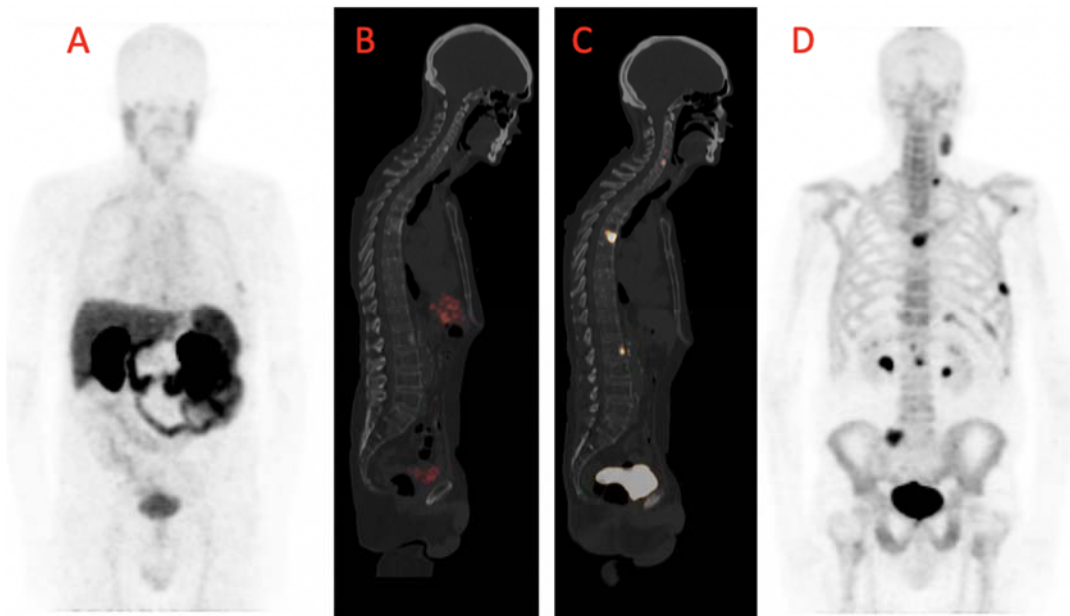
A 68-year-old male with hormone-resistant prostate cancer, Gleason score of 3+4, and a serum PSA of 11.44 ng/mL at the time of imaging. His treatment history includes radical prostatectomy, androgen deprivation therapy, radiotherapy for bone pain palliation, and four cycles of $[^{225}\text{Ac}]\text{-PSMA-617}$. MIP (A) and sagittal fused PET/CT (B) images of $[^{68}\text{Ga}]\text{-PSMA-11}$ PET/CT showed no lesion with avidity for the tracer significantly above background activity. In contrast, fused sagittal PET/CT (C) and MIP images (D) of the $[^{68}\text{Ga}]\text{Ga-NODAGA}^{\text{ZOL}}$ PET/CT show multiple sites of skeletal metastases.
